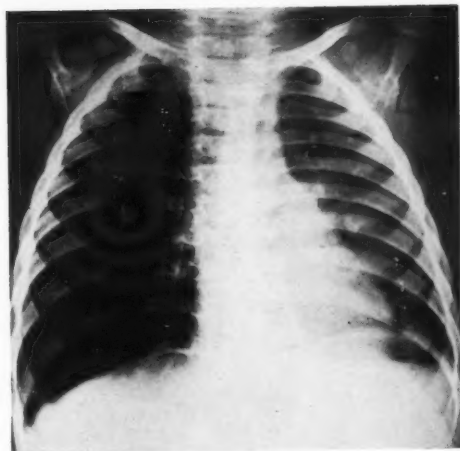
Chest radiograph on admission to Harefield Hospital. The typical features of unilateral obstructive emphysema: mediastinal shift, depressed diaphragm and widened rib spaces.
